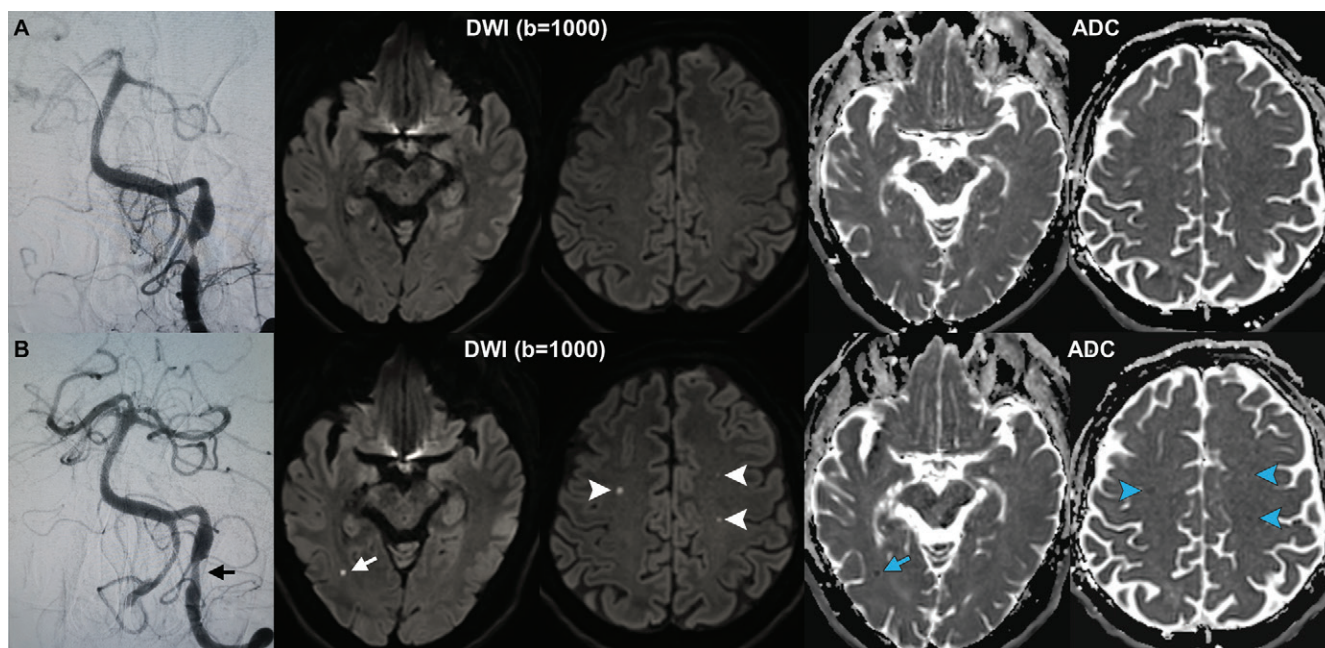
Images in a 51-year-old man with recurrent dizziness for 1 month who was diagnosed with severe stenosis in the V4 segment of the left vertebral artery. (A) Image from digital subtraction angiography (left) shows severe stenosis at the intracranial segment of the left vertebral artery. There is no new ischemic brain lesion on the pretreatment diffusion-weighted imaging (DWI) scans and apparent diffusion coefficient (ADC) maps. The stenosis lesion was dilated with a 3.0 × 1.5-mm balloon. (B) Image from digital subtraction angiography (left) obtained after balloon angioplasty shows that the degree of stenosis in the left vertebral artery was significantly improved (arrow). Posttreatment DWI scans and apparent diffusion coefficient maps show a small new ischemic lesion in the right temporal lobe (arrows) that was located in the territory of the treated artery and multiple small subcortical new ischemic lesions of the bilateral anterior circulation (arrowheads), which were located beyond the territory of the treated artery (in the territory of the catheterized artery).
